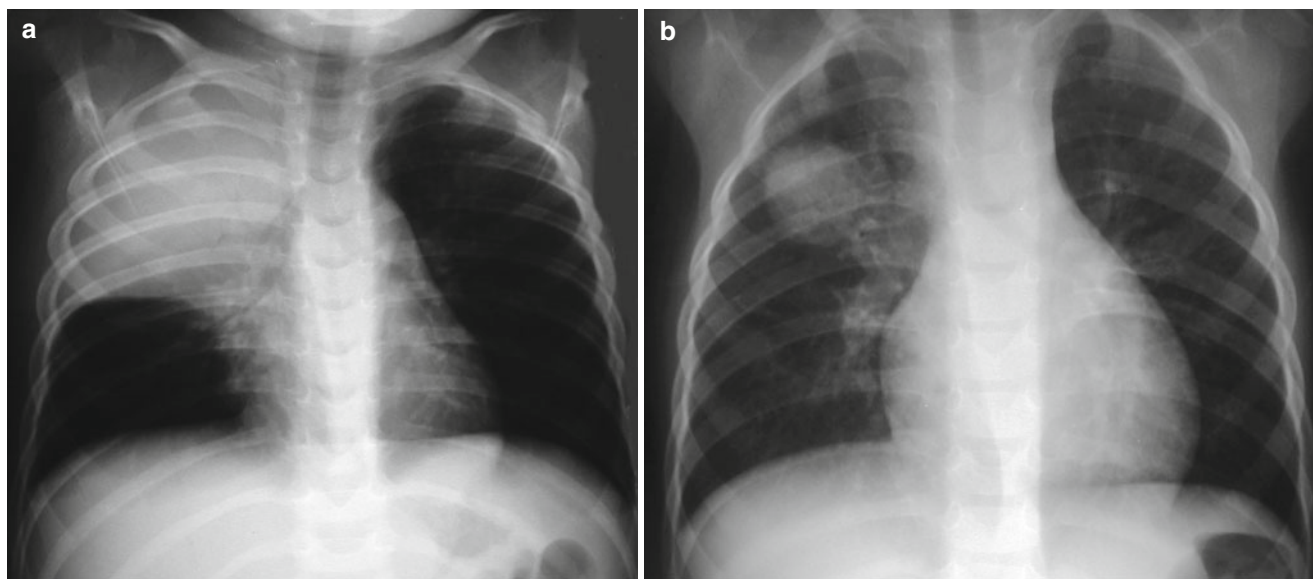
Bacterial pneumonia. Chest radiographs of a 3-year-old girl with high fever, cough, and leukocytosis (a) demonstrate complete opacification of the right upper lobe. Image (b) shows a round, mass-like consolidation compatible with round pneumonia
